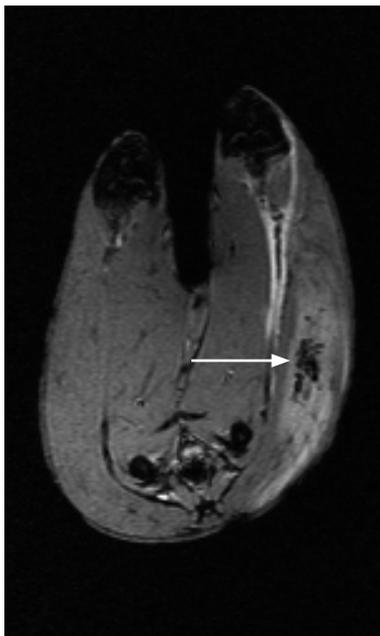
MR image one day after shock wave exposure, transversal section
